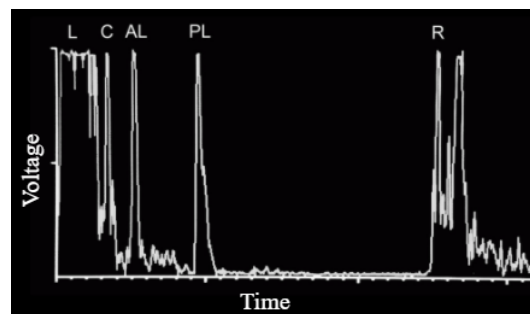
A-mode scan in ophthalmic ultrasound diagnostic. Peaks correspond to eyelid (L), cornea (C), anterior (AL), and posterior lens (PL) surfaces and retina (R). (Adapted from [30])
